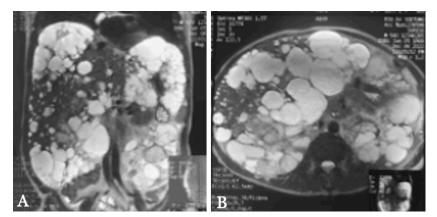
Abdominal magnetic resonance imaging (MRI) suggests an enlargement of both kidneys, containing multiple cysts partially filled with blood (A). Hepatomegaly with multiple cysts in the right and left liver lobes are also observed, with the highest cyst $(6.5 \times 6.3 \times 5.4 \text{ cm in size})$ found in the segment V of the right lobe (B).
